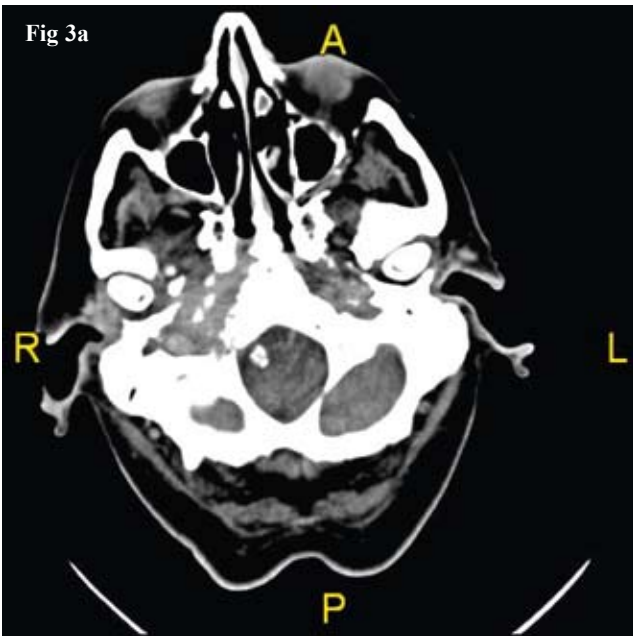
Axial computed tomography showing extensive soft tissue changes in (a) and bone erosion involving the right temporal bone extending to the foramen magnum and involving the lower cranial nerves (IX, X, XI, XII) in (b).
